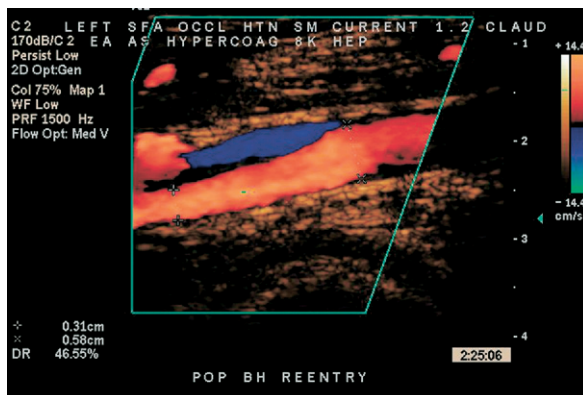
Intraoperative color Doppler image of the popliteal artery behind the knee after re-entry during subintimal dissection, depicting the origin of dissection. Note the typical bidirectional flow pattern represented by *red* (true lumen) and *blue* (false lumen).
